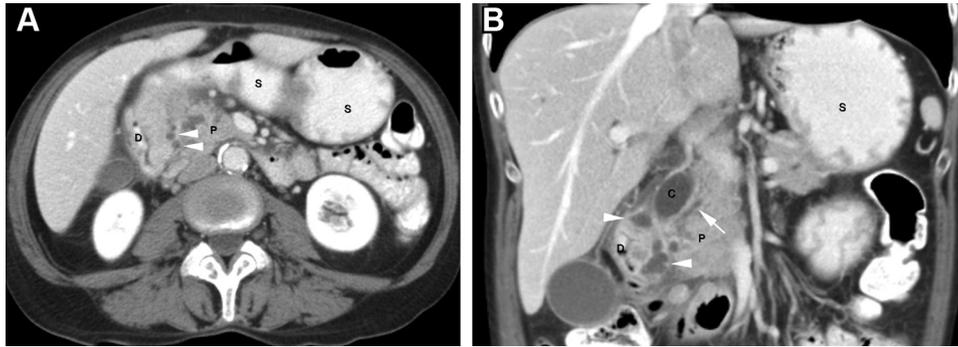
Groove pancreatitis. A 51-year-old woman with groove pancreatitis. The original radiologist described thickening of the duodenal wall with obstruction of the common bile duct, suggestive of malignancy. Both expert radiologists diagnosed groove pancreatitis with typical small cysts in the pancreatic groove (*arrowheads* in *A* and *B*). (*A*) Axial CT image showing thickening of pancreatic groove (D = duodenum, P = pancreatic head, S = stomach). (*B*) Coronal reformatted CT image depicts the markedly dilated common bile duct (C) and normal diameter of pancreatic duct (*arrow*).
